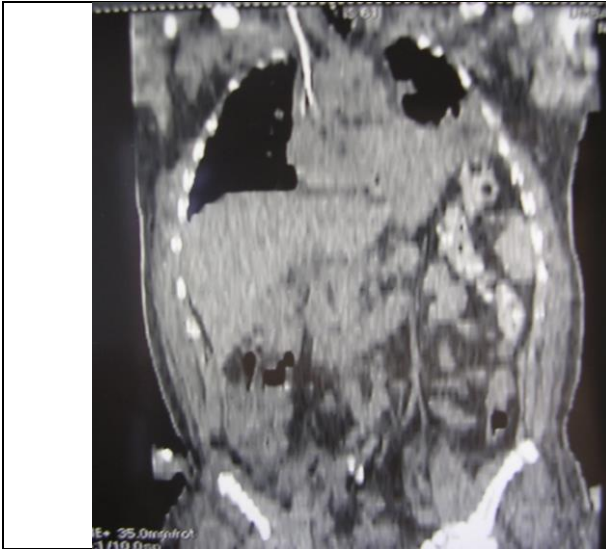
Contrast enhancement computed tomography reveals left diaphragmatic rupture with concomitant left hemothorax / (the author's database).
